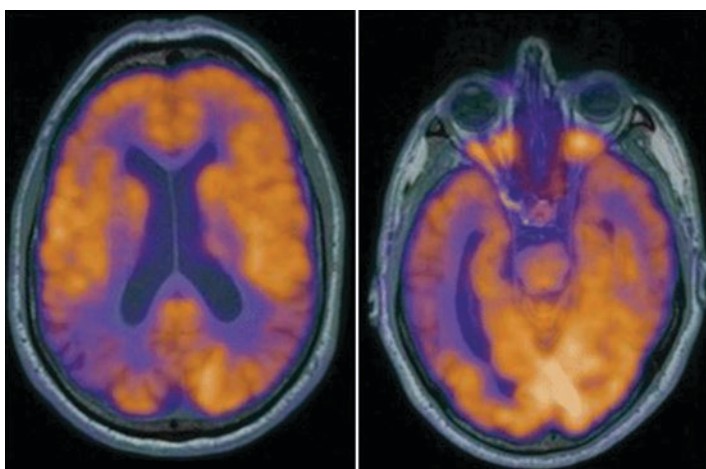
FDG PET/MRI in a patient with early AD demonstrating glucose hypometabolism in the parietal and temporal lobes (right >left)
